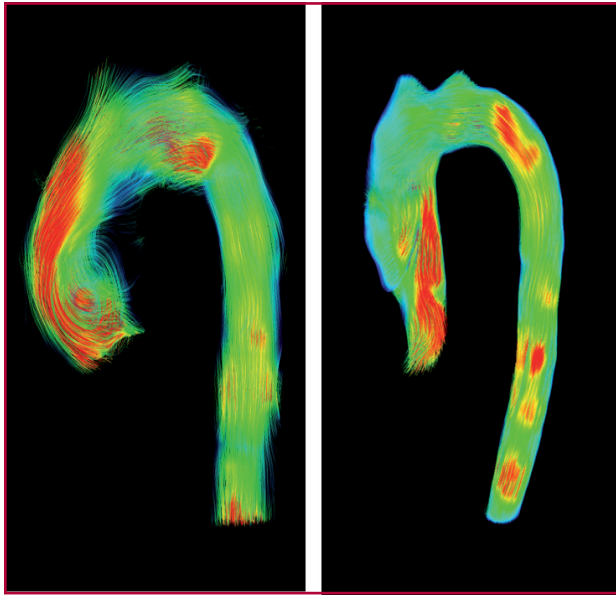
4D-flow cardiac MRI in BAV patients.
